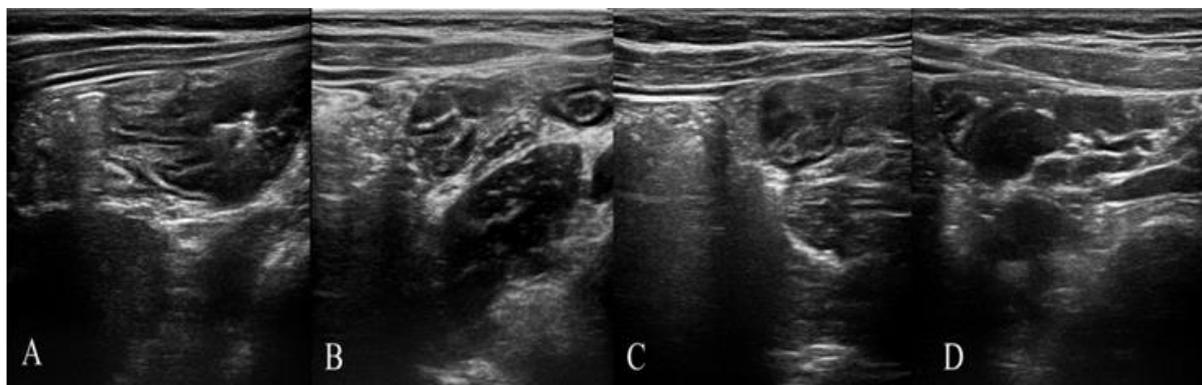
The sonographic feature of terminal ileum: A) Visibility of ileocecal valves and Peyer's patches as confluent hypoechoic nodules, B) Visibility of appendix in posterior-inferior aspect of terminal ileum, C) Specific appearance of terminal ileum between other bowels, and D) Terminal ileum and mesenteric lymphadenitis.
